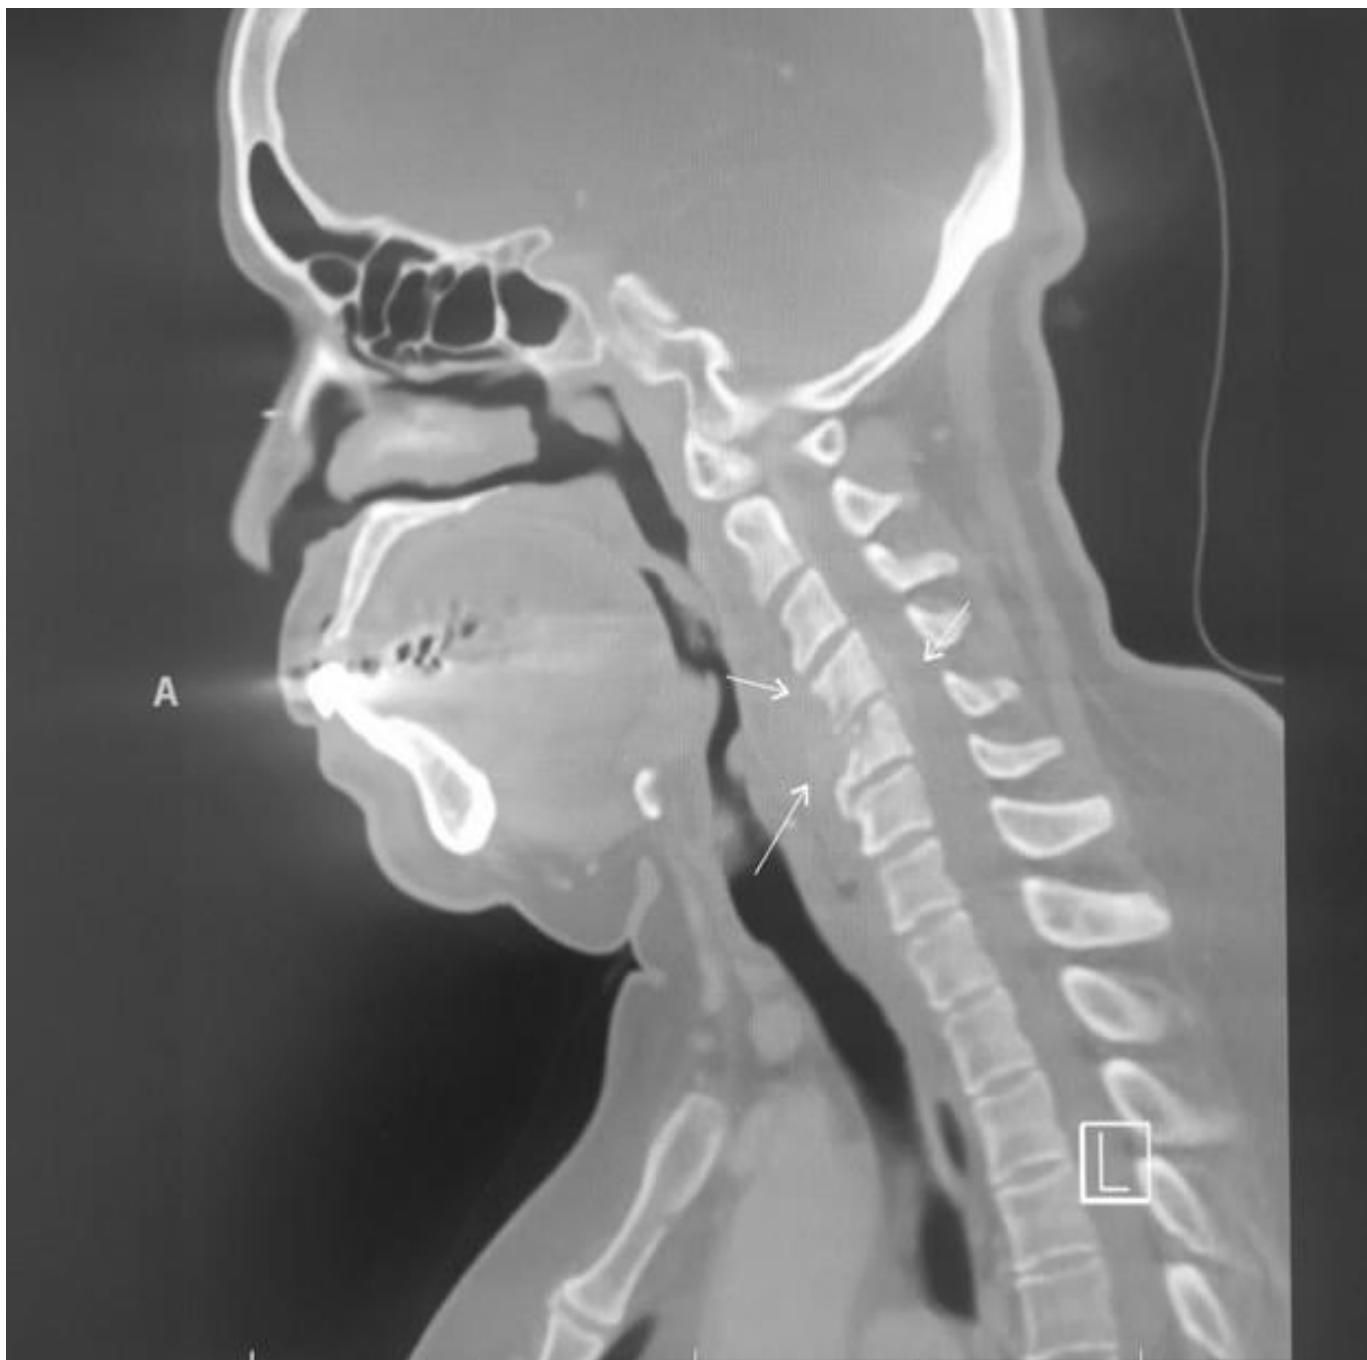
Post-Operative CT Neck with Contrast
